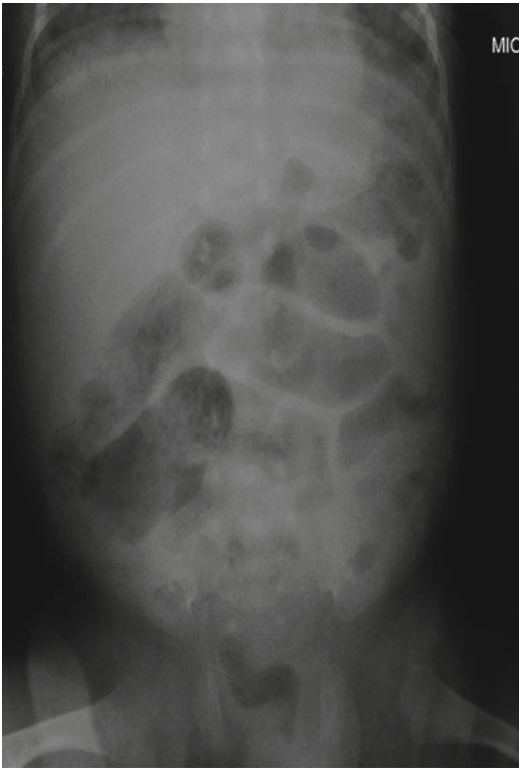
Abdominal plain film in newborn with NEC: stage II of Bell classification: in the left abdominal quadrant, there is a distended loop with intramural gas with foamy aspect
